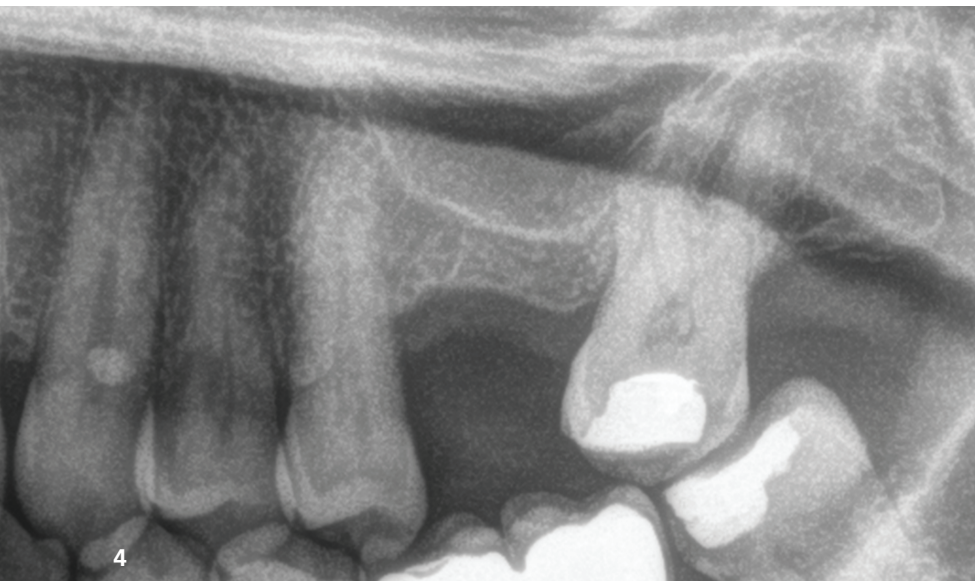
Initial X-ray of the patient showing the edentulous section of the second quadrant to be rehabilitated with a short single implant.
